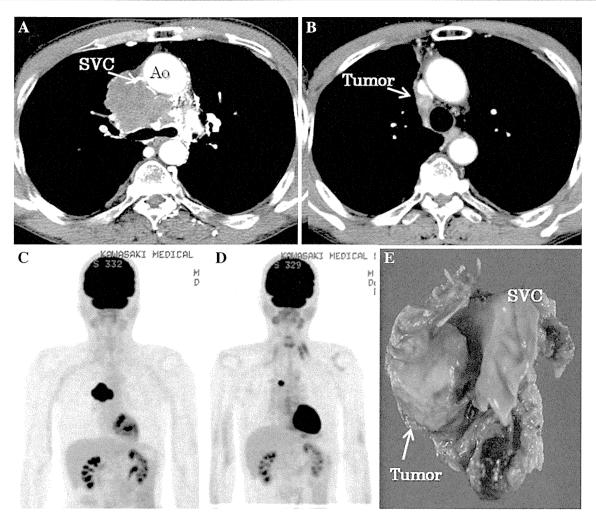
a Enhanced CT revealed a solid mass 67 mm in diameter with severe constriction of SVC in the middle mediastinum. b Enhanced CT following induction therapy showed 66 % reduction in tumor size. c FDG-PET revealed intense uptake of the tumor without any
